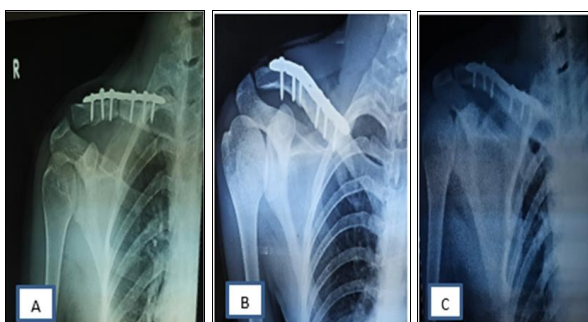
Radiograph of patient treated surgically A) at 6 weeks, B) at 3 months, C) at 6 months
